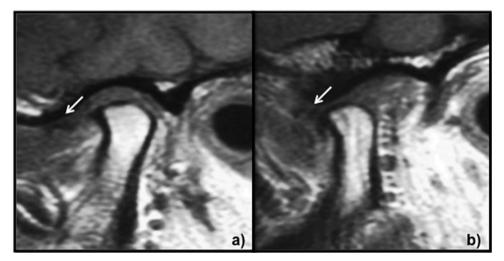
T1-weighted sagittal view: (a) mouth closed – the articular disc (hypointense area, arrow) is in a position prior to 11:30 h in relation to the mandibular condyle; (b) mouth open – the articular disc remains in the displaced position, characterizing disc displacement without reduction (DDWoR).
